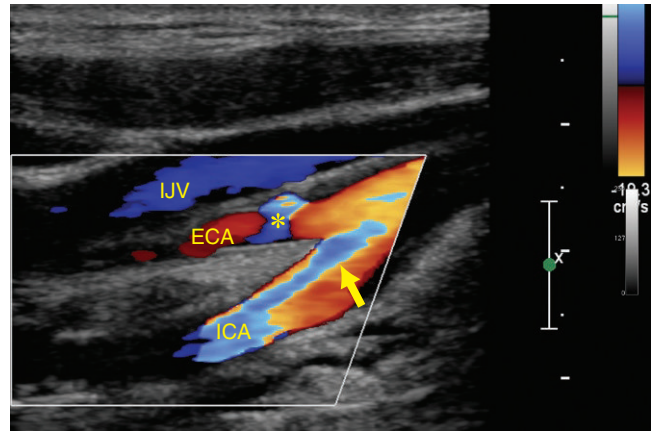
Color Doppler of the bifurcation demonstrates aliasing as the cause of the color in the internal carotid artery (ICA). The aliasing (arrow) changes from red and yellow (correct direction) and wraps around to light and dark blue (aliased direction). This is not due to stenosis but rather to the low Doppler scale, which demonstrates the faster moving blood in the center of the vessel. The internal jugular vein (IJV) is blue and demonstrates the correct direction of blood back to the heart (toward the feet). The external carotid artery (ECA) also has an area of blue (*). This is not due to aliasing but rather to flow reversal created by the bifurcation. Note the color changes but has a black line around it indicating true reversal.
